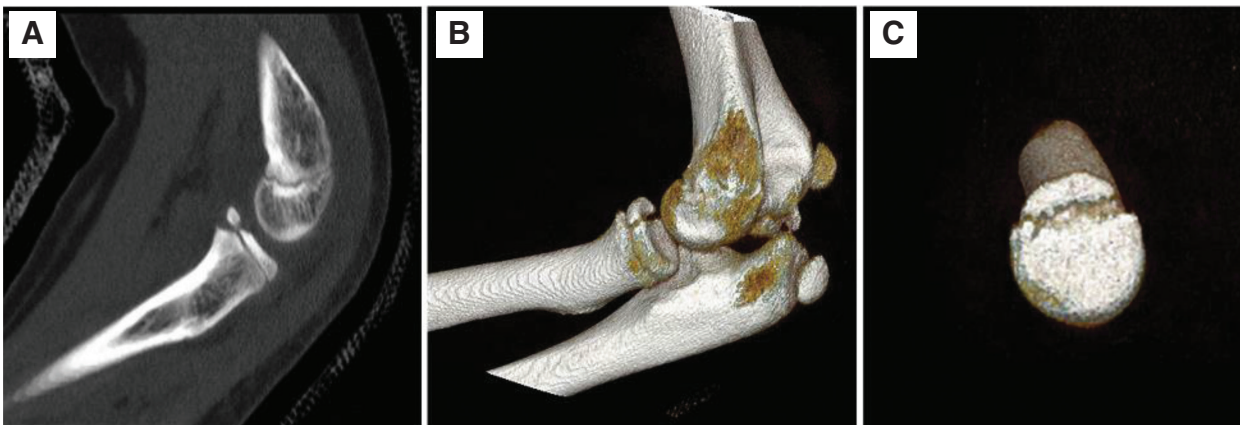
(A) Sagittal CT reconstruction depicting an intra-articular radial head stress fracture nonunion. (B) Three-dimensional CT scan highlighting the anterior location of the marginal radial head lesion. (C) Three-dimensional CT reconstruction with humeral subtraction depicting the small portion of the anterior surface area affected. (Images courtesy of Children’s Orthopaedic Surgery Foundation).
